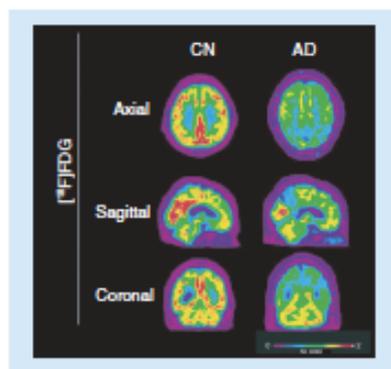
Representative ^{18}F FDG images in a cognitively normal subject and in a patient with Alzheimer's disease. Metabolic imaging with ^{18}F FDG PET in AD shows the characteristic pattern of reduced tracer emission, comprising bilateral parietal, temporal and posterior cingulate regions. In contrast, metabolism within these regions is preserved in the cognitively normal subject.
